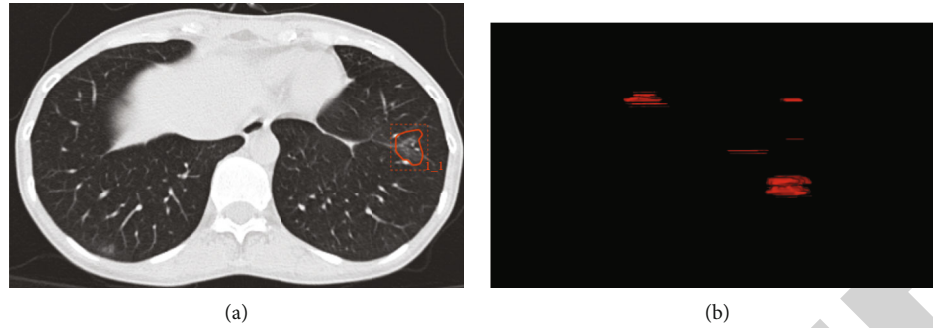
A case of confirmed mild COVID-19. A 33-year-old female presented with a 2-day history of fever and cough. (a) CT imaging revealed diffuse pure GGO with distribution in the left lower lobe. The area of the lesions was delineated on the axial. (b) The reconstructed images.
